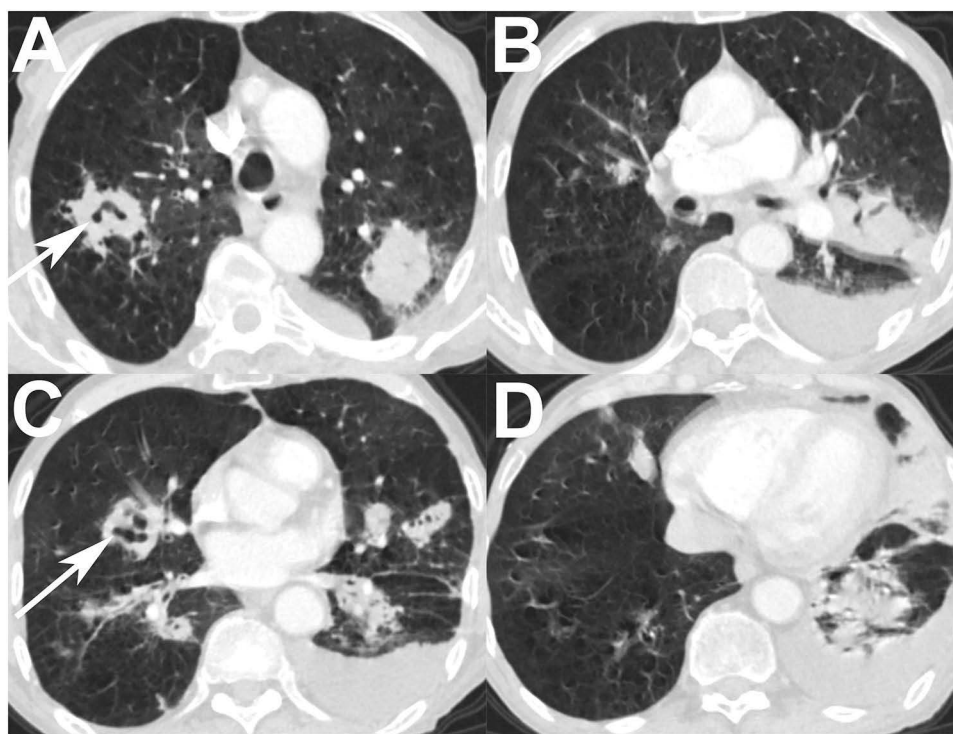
(A): CT image of the lung window shows patchy high-density shadows in both upper lobes, the formation of a thick-walled cavity in the upper right lobe (white arrow), and pleural effusion on the left side. (B): CT image of the lung window shows an increase in the mass shadow adjacent to the left pulmonary hilum relative to the previous scan, accompanied by an increase in the left pleural effusion, relative to the previous scan. (C): CT image of the lung window shows multiple patchy high-density shadows in both lungs, with some cavity formation (white arrows) and uneven thickening of the walls. (D): CT image of the lung window shows consolidation in the left lingual lobe and lower left lobe, together with an increase in pleural effusion on the left side relative to the previous scan.
